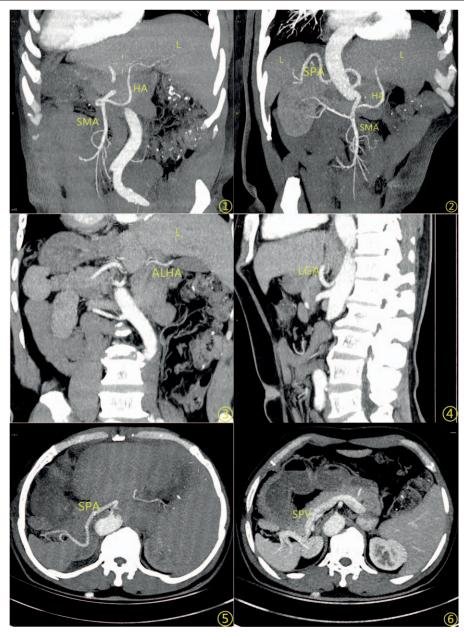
Computed tomography showing transposition of the abdominal organs. ALHA=accessory left hepatic artery, HA=hepatic artery, L=liver, LGA=left gastric artery, SMA=superior mesenteric artery, SPA=splenic artery, SPV=splenic vein.
